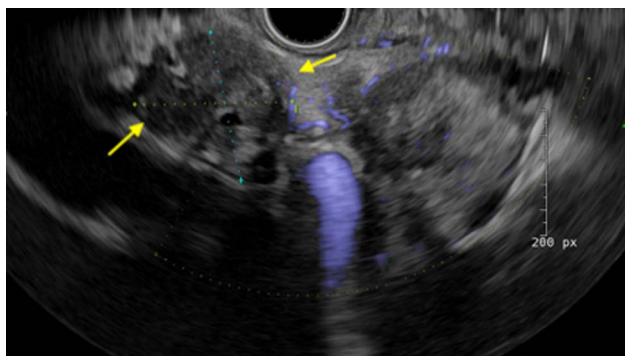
Endoscopic ultrasound showing an enlarged lymph node (arrows).
